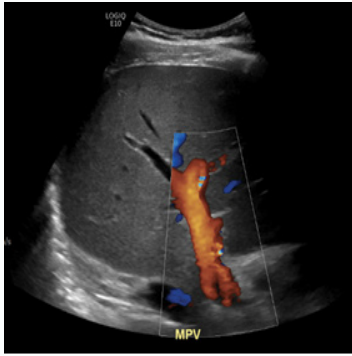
Ultrasound of the abdomen with Doppler image. Arrows indicate a patent main portal vein.
